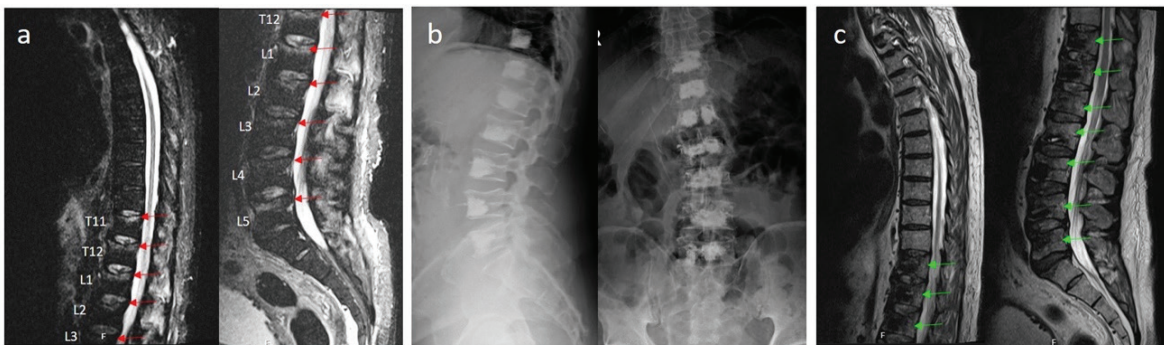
A 27 years old male patient with a history of prolonged steroid use and no evidence of trauma presented with persistent back pain lasting for one week. A whole-spine MRI revealed multilevel vertebral body compression fractures with acute compression and edema observed on STIR sequences. These were treated with single-session multilevel KP. (a) Pre-operative STIR-sequenced MRI images show acute compression fractures at seven levels (T11-L5) marked with red arrows. (b) Post-operative X-ray images display cement fillings without any cement leakage into the spinal canal. (c) Post-operative STIR-sequenced MRI images demonstrate cement fillings covering all edematous areas, indicated by green arrows
